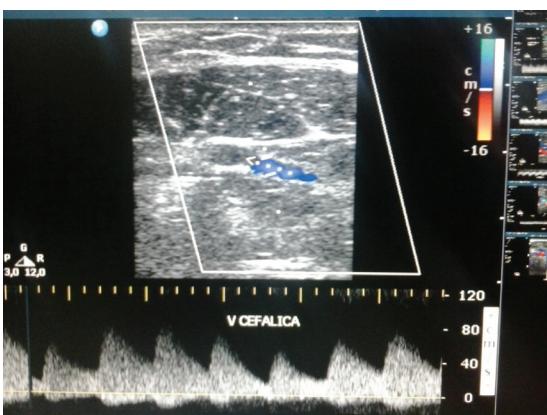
Doppler ultrasound showing right cephalic vein with reversed, pulsating flow.
